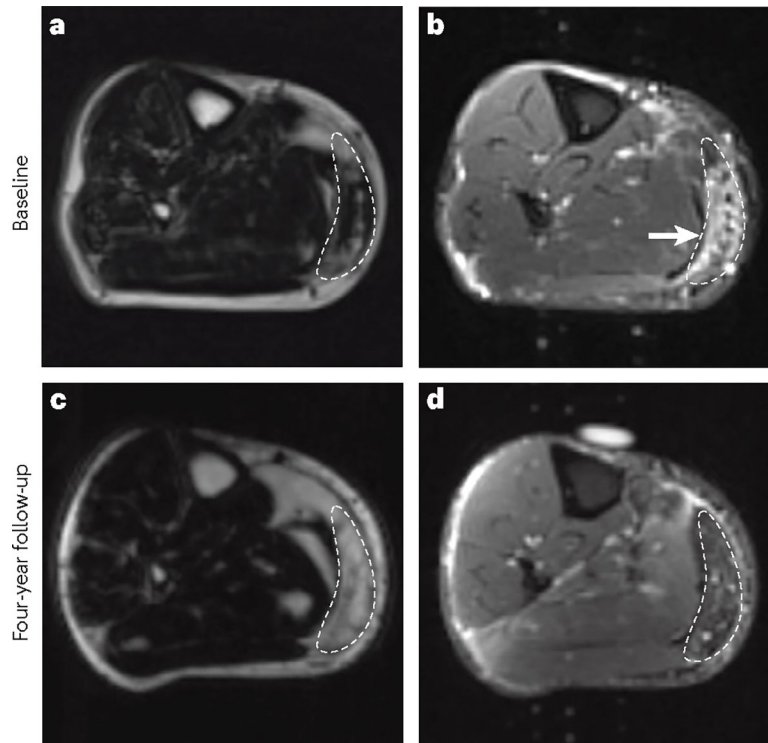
Progression of facioscapulohumeral muscular dystrophy can be measured with MRI. a, An MRI scan (Dixon sequence) showing mild-to-moderate fatty infiltration in a region of interest (outlined) of the right medial gastrocnemius muscle. b, A corresponding short tau inversion recovery image of the same patient shows a hyperintense signal (arrowhead) indicative of muscle inflammation. c, Follow-up MRI scan (Dixon sequence) of the right medial gastrocnemius muscle 4 years later of the same patient, showing facioscapulohumeral muscular dystrophy progression to near-complete fatty infiltration of the muscle tissue. d, A corresponding short tau inversion recovery image at the same time point shows that the hyperintense signal (muscle inflammation) has disappeared.
